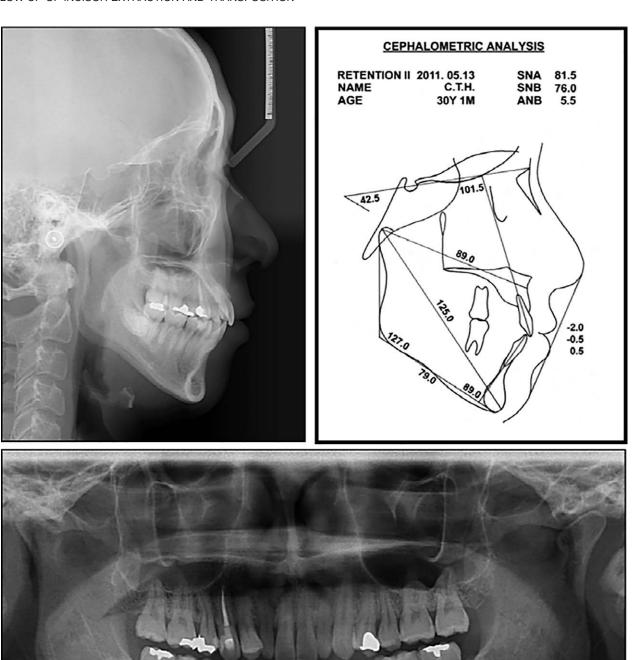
Fifteen-year postretention radiographs: lateral cephalogram, lateral cephalometric analysis, and panoramic radiograph.
